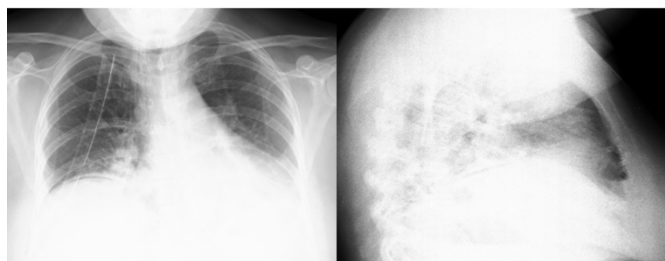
Postoperative posteroanterior and lateral chest X-ray of the patient.
